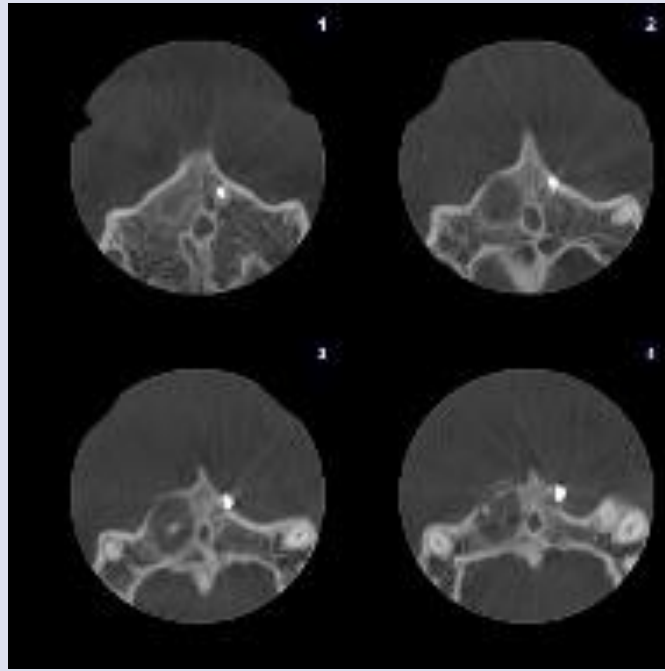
Cone beam computed tomography (CBCT) Axial sections showing the position of the residual endodontic material and the bone defect.
